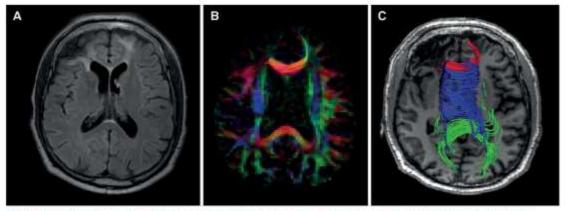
Axial FLAIR image of an adult male patient with chronic post-traimatic sequelae shows gliosis in the frontal lobes, mainly in the right side (A). FA colormap demonstrates paucity of white matter fibers and reduction of brightness due to reduction of FA values in the frontal lobes, more pronounced in the right side (B). DTI-based tractography of the splenium, body and genu of the corpus callosum (represented in green, blue, and red colors, respectively) shows premature termination of streamlines of peripheral fibers of the genu projecting to or from the prefrontal regions coincidental to the areas of low signal intensity on the axial T1-weighted image (C).
